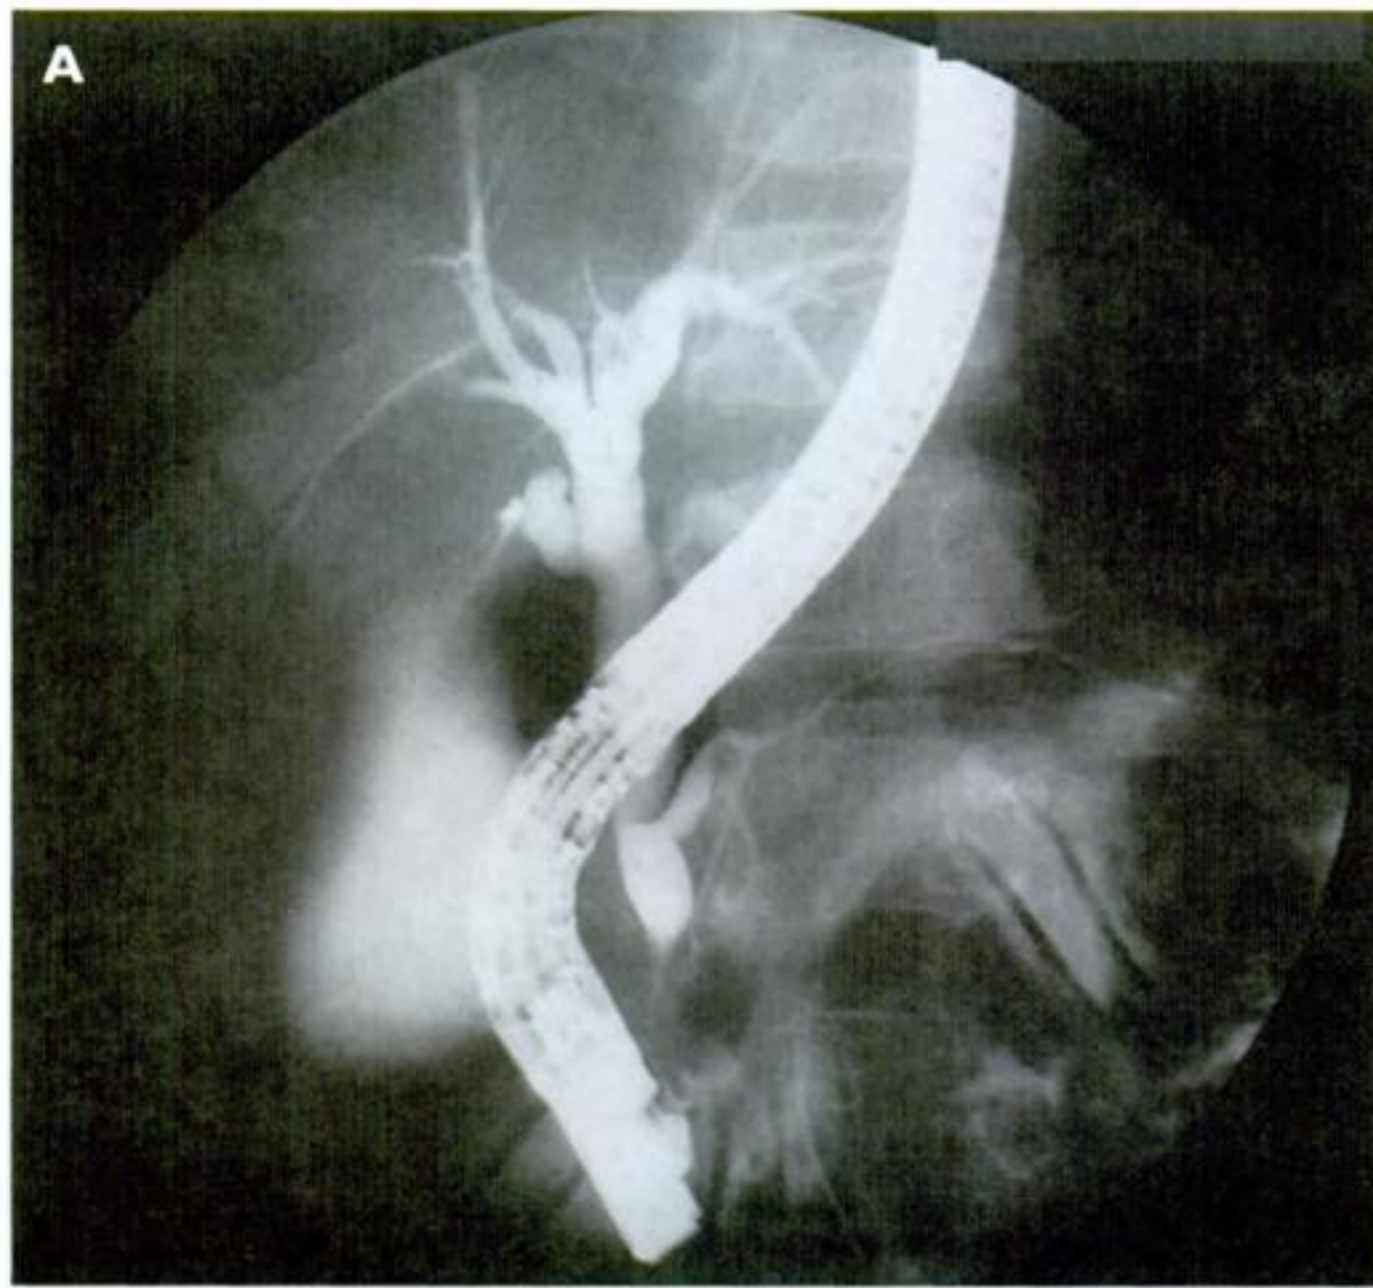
Anomalous Pancreaticobiliary Junction. Severe acute pancreatitis in a 13-year-old boy. *A*, Cannulation of the major papilla; injection of common bile duct and Wirsung duct reveals an anomalous pancreaticobiliary ductal junction type PB: long common channel with pancreatic duct joining the common bile duct. Note the diffuse dilatation of the biliary tract. *B*, After retrieval of duodenoscope, X-ray of the patient in dorsal decubitus better demonstrates the long common channel cephalad to the sphincter of Oddi.
